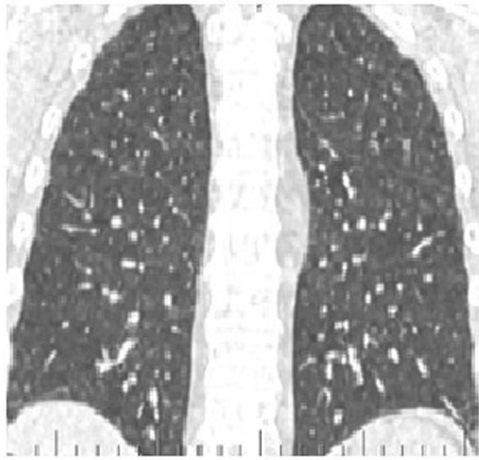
CT of lungs after plasty of the skull base defect. (regression of inflammatory changes).
